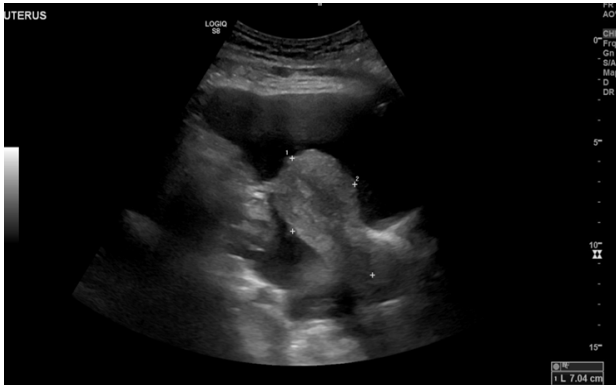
An ultrasound of the pelvis showed a massive collection of fluid within the pelvis. The deepest pool measured about 11.6 cm in AP diameter and multiple echogenicities was visualised within the fluid.
